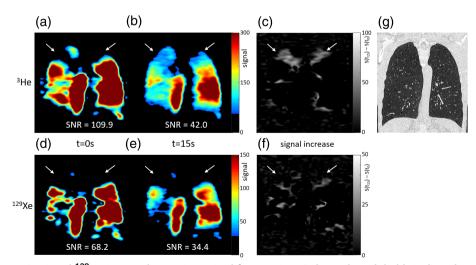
³He images (top) and ¹²⁹Xe images (bottom) acquired from patient 3 during breath-hold; (a,d) at the start of the imaging sequence, t = 0 sec, and (b,e) after 15 seconds, both shown with the same signal range. (c,f) Maps of signal increase from t = 0 sec to t = 15 sec. White arrows highlight regions of lung where ³He signal increased over time, but ¹²⁹Xe signal did not. (g) CT showed severe centrilobular emphysema and hyperinflation, and all fissures appeared intact. Mean SNR over the whole lung ventilated volume for that timepoint is displayed for a, b, d, and e.
